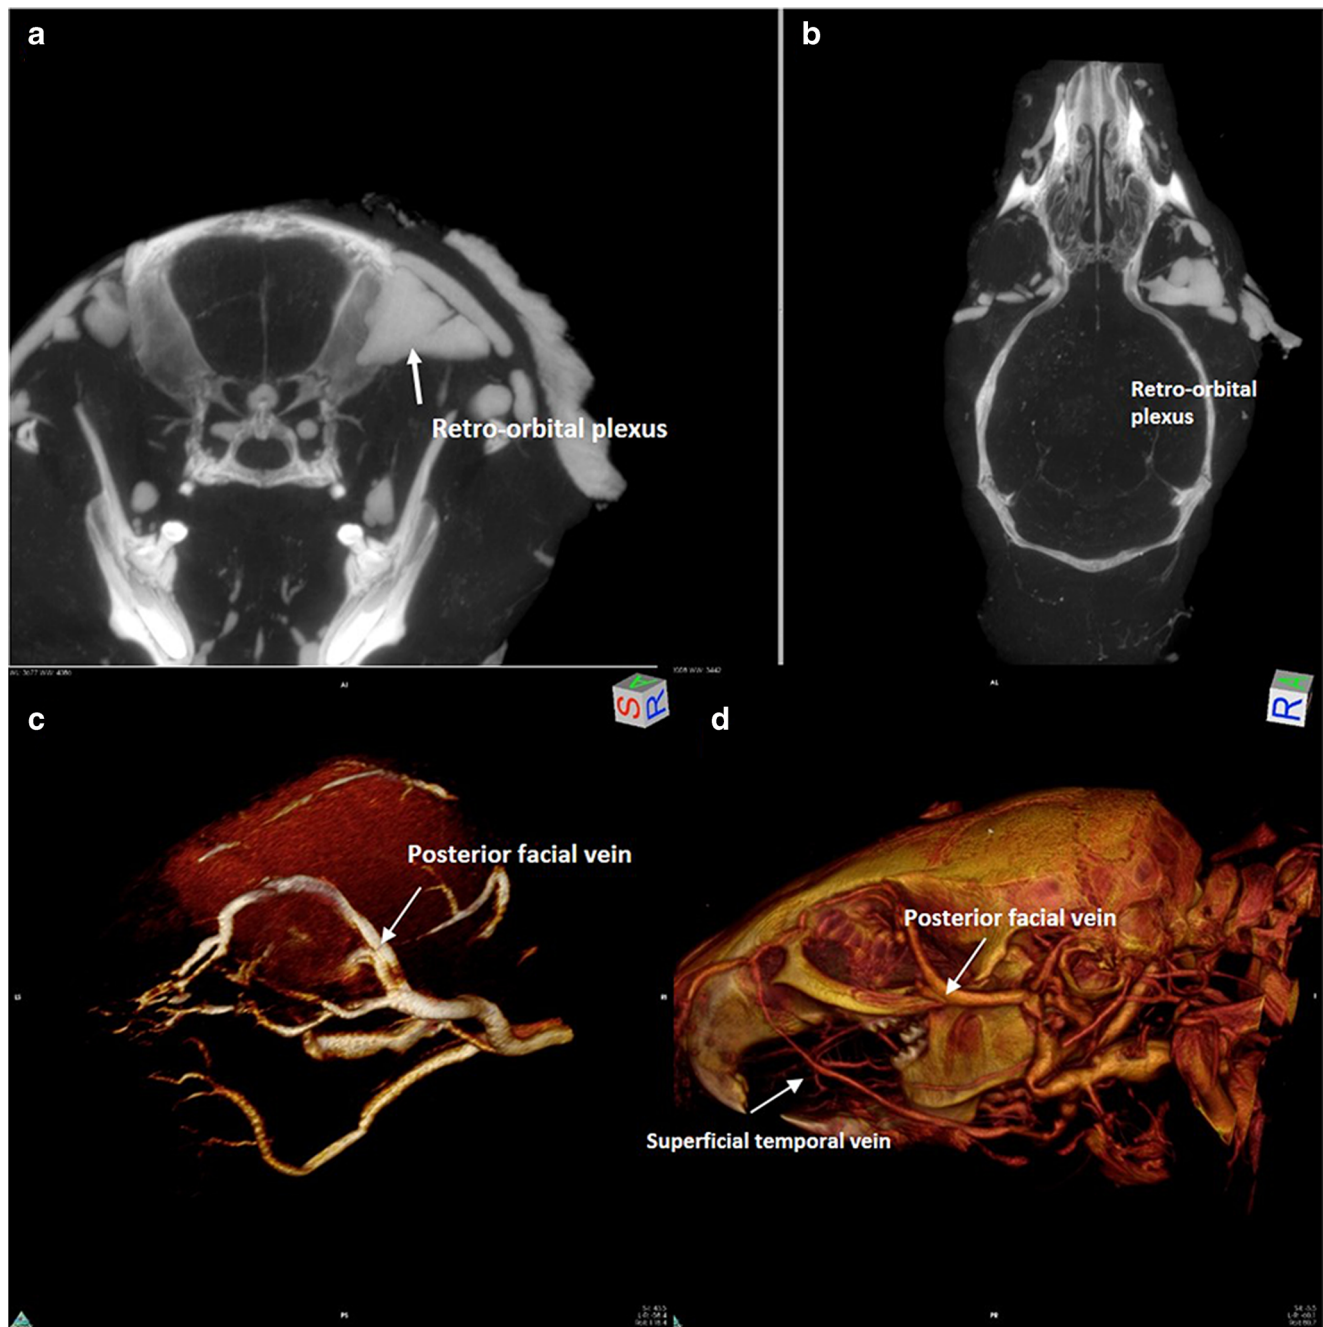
Magnetic resonance angiography with 3D rendering acquisition of the orbital region. Upper row: (a) axial and (b) coronal computed tomography slice. Lower row: 3D rendering of magnetic resonance angiography acquisition of the left orbital region ((c) antero-lateral view). 3D rendering of silicon-enhanced computed
